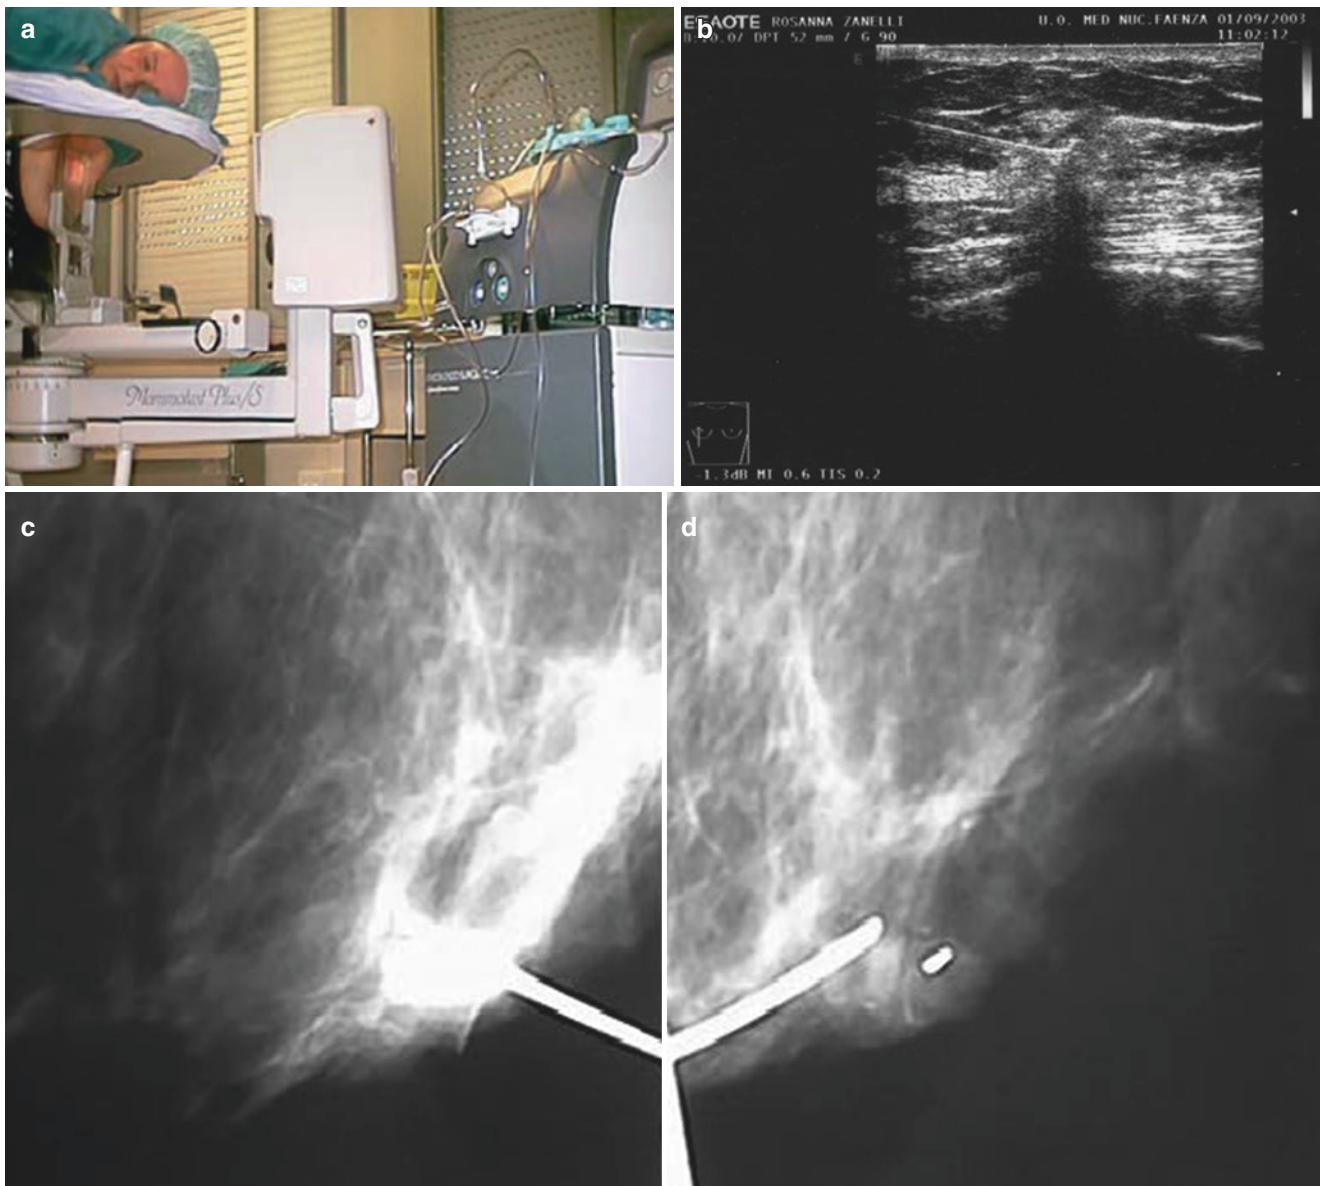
Injection of ^{99m}Tc -MAA under (a, c, d) stereotactic or (b) ultrasound guidance
